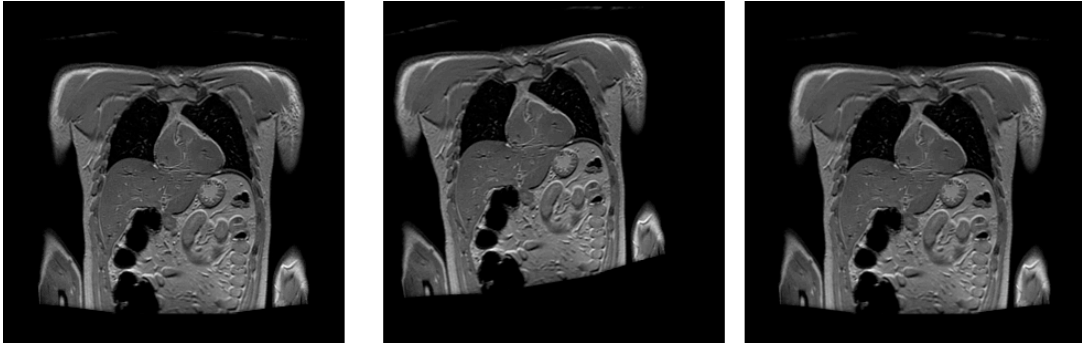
Rectification of PD-weighted MRI from THORAX test set
